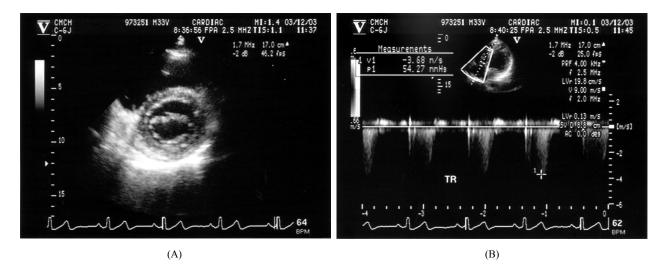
Initial echocardiography revealing the degree of pulmonary arterial hypertension (pulmonary artery pressure: 64 mmHg)
